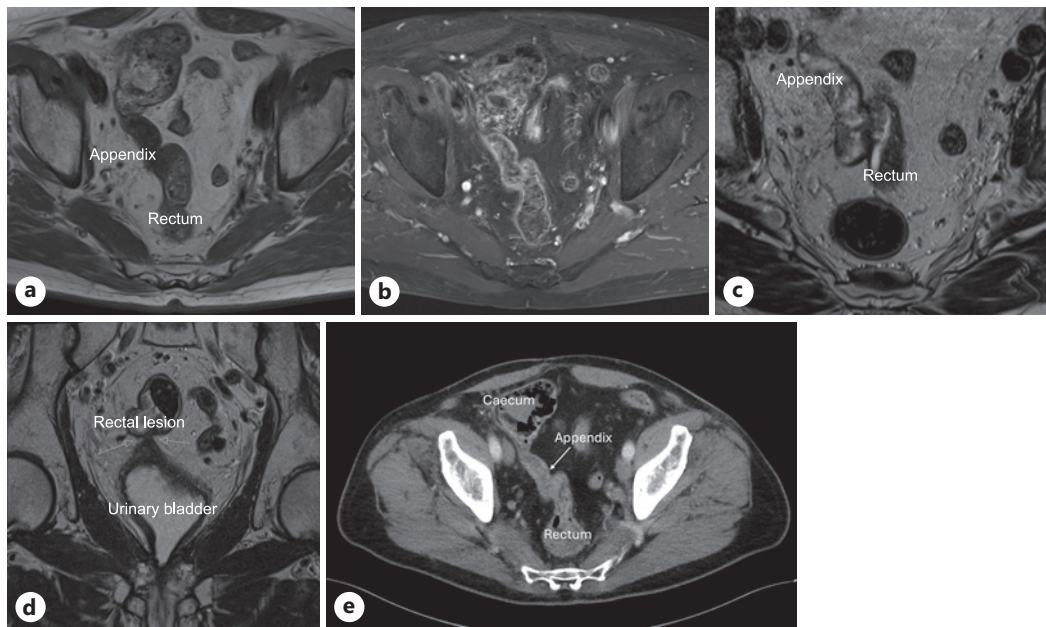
a Axial T1-weighted image shows a thickened appendix arising from the caecum, coursing posteriorly and abutting the right lateral wall of the rectum. There is a T1 hypointense appendiceal tumor invading the rectosigmoid, with loss of the intervening fat plane. b Axial fat-suppressed post-contrast T1-weighted image demonstrates heterogeneous enhancement within the appendiceal and rectal components of the tumor. c High-resolution axial T2-weighted images without fat suppression show heterogeneous T2 hyperintense tumor involving the appendix. The distal end of the appendix abuts the right lateral wall of the rectum. Tumor invades the right lateral wall of the rectum, forming an intraluminal carpeting lesion within the rectum. d High-resolution coronal oblique T2-weighted images demonstrate tumor adherent to the wall of the urinary bladder, resulting in tenting of the bladder wall. e Axial contrast enhances CT image through the pelvis shows an enlarged appendix with irregular thickening of its walls. The appendix courses posteriorly and the tip of the appendix is adherent to the rectosigmoid on the right side.
